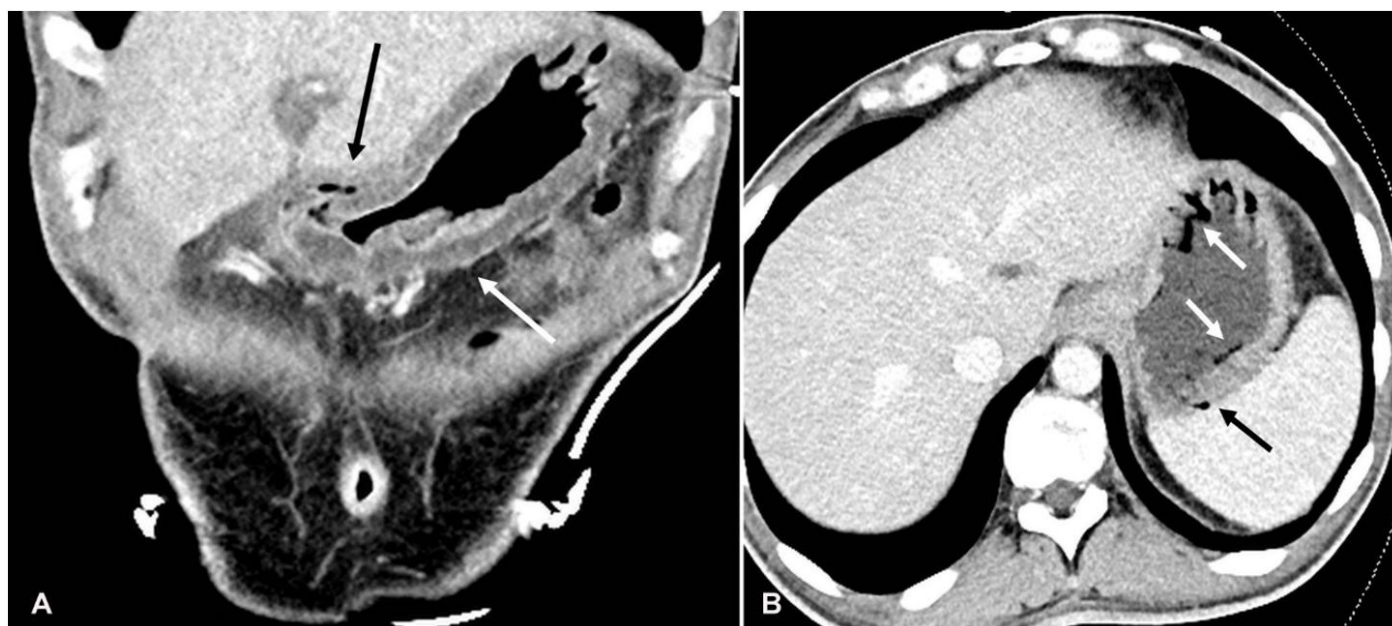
Abdominal CT scan: Emphysematous Gastritis. A – Coronal plane of the thickened edematous gastric wall (white arrow) and gas noted in a mural vein (black arrow); B – Axial image demonstrates gas in the mucosa of the gastric wall (white arrows) and in a mural vein (black arrow).
